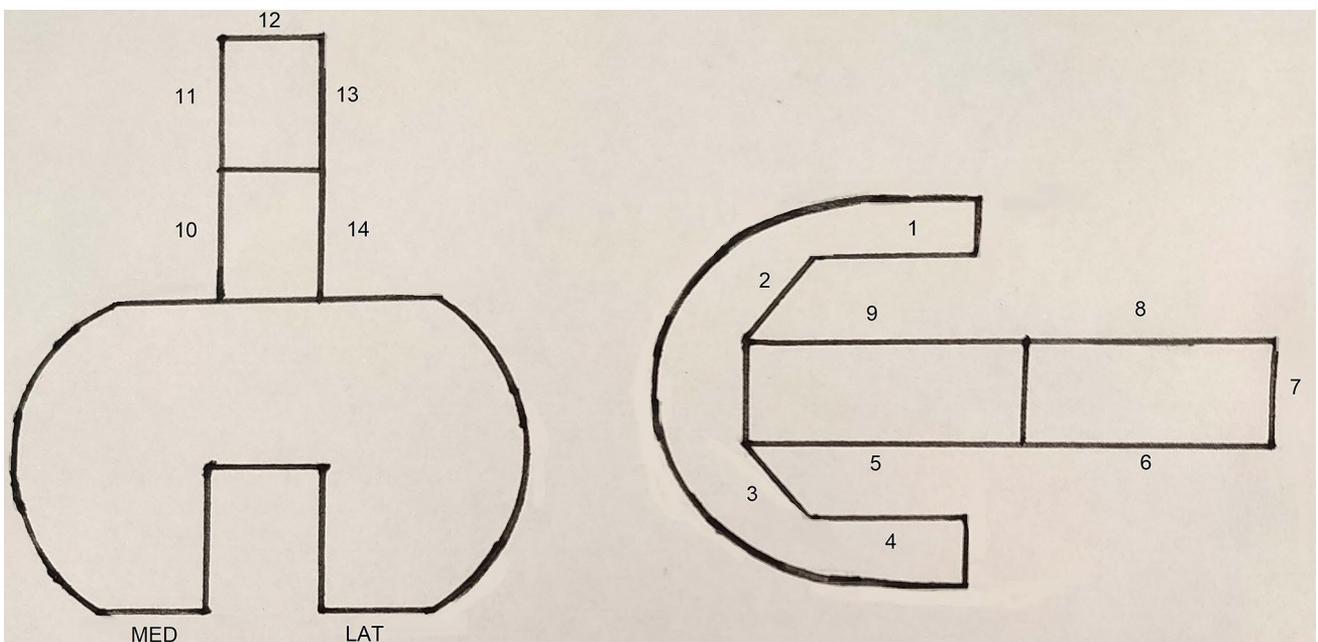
Measurement of the thickness of the radiolucent lines (RLLs) in the femoral component of the revision knee prosthesis according to the modified Knee Society radiographic scoring system.
